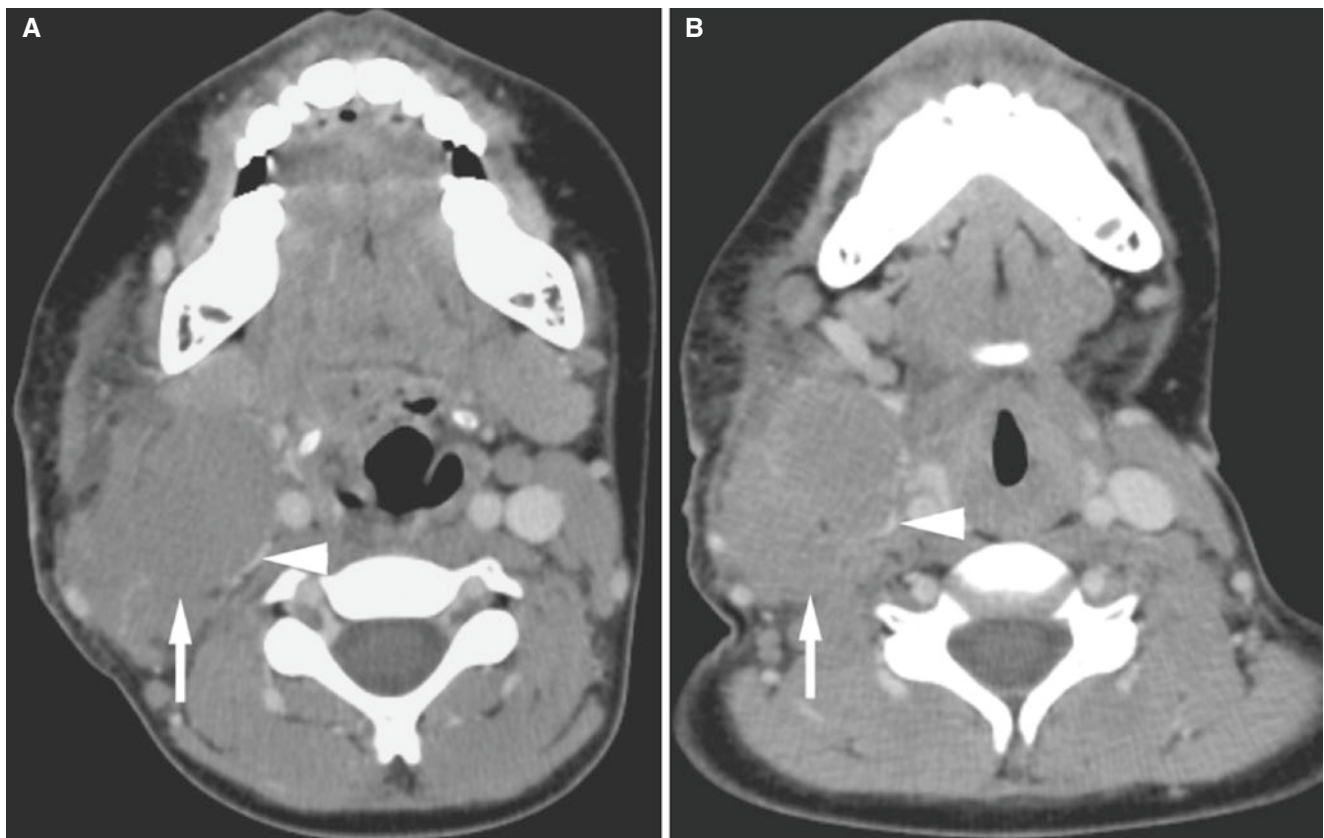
Burkitt's lymphoma; 7-year-old female with a 2-week history of large nontender neck mass. Axial post-contrast CT images ((B) more caudal than (A)) show a large soft-tissue mass (*arrows*) severely compressing internal jugular vein (*arrowheads*) and pushing midline
